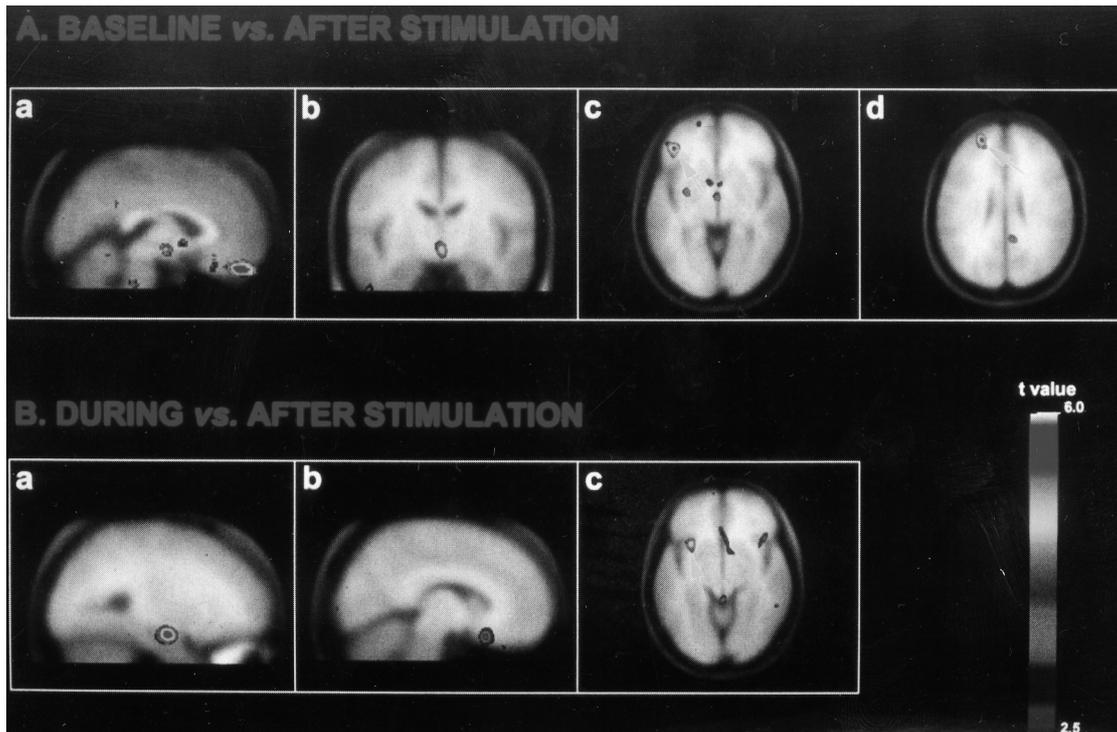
PET data from 'baseline – after' and 'during – after' subtractions coregistered with an average MRI volume of 305 normal subjects and mapped in Talairach space. (A) Baseline (pain) compared with stimulator off (no pain). Significant rCBF increases were observed in BA 11 (a), the hypothalamus (b), BA 47 (c) and BA 9 (d). (B) Stimulation on compared with after stimulation (no pain) condition. Significant rCBF increases occurred in the amygdala (a), BA 11/25 (b) and the anterior insula (c) (with permission).
